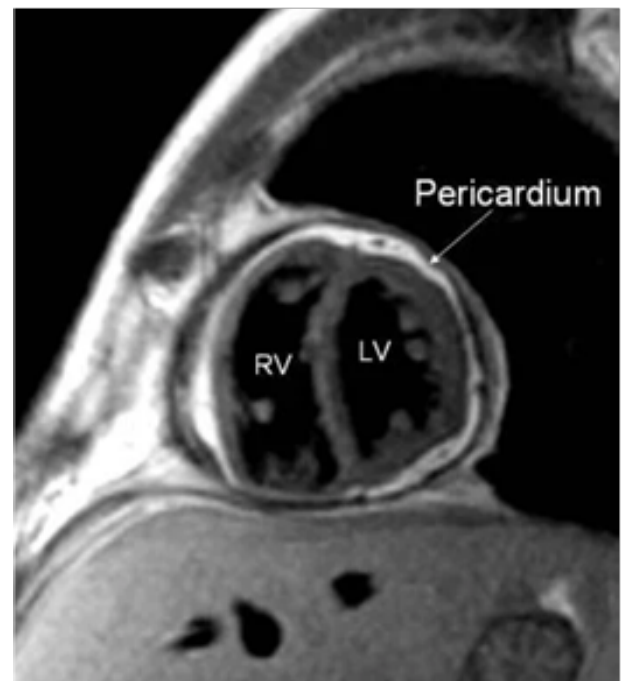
THICKENED PERICARDIUM AS EVIDENCED IN CARDIAC MRI OF A PATIENT WITH CONSTRICTIVE PERICARDITIS.
